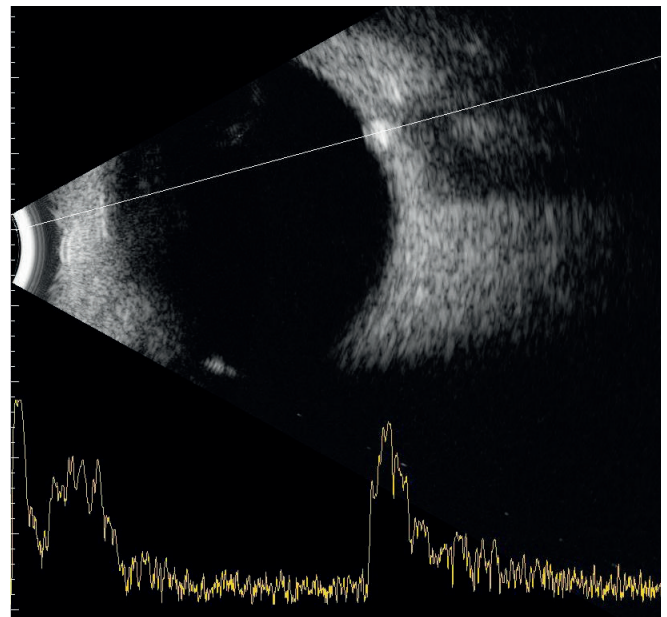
Ocular ultrasound demonstrates optic disc drusen as hyper-echogenic focus within the optic disc
